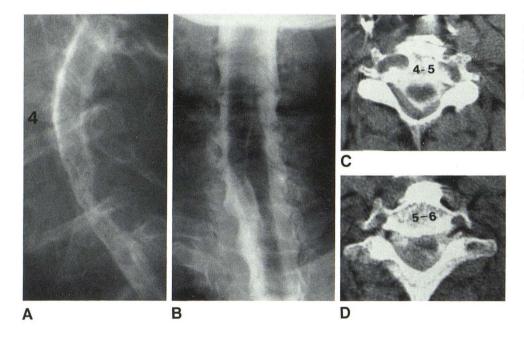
Epidural hematoma. A, Posterior extradural mass is shown myelographically to extend inferiorly from C4 level. B, Linear contrast density overlying cord shadow represents displaced posterior subarachnoid space. C and D, CT metrizamide myelograms delineate relation of hematoma to cord more clearly.
